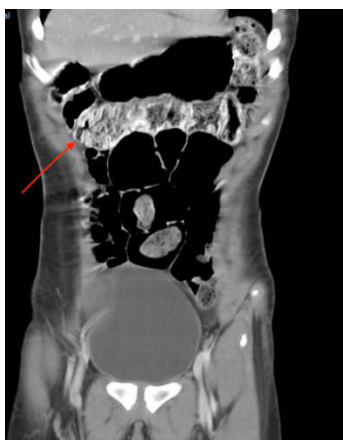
Contrast-enhanced CT scan showing marked distention of the colon and a large fecaloma extending from the transverse colon to the rectosigmoid colon
